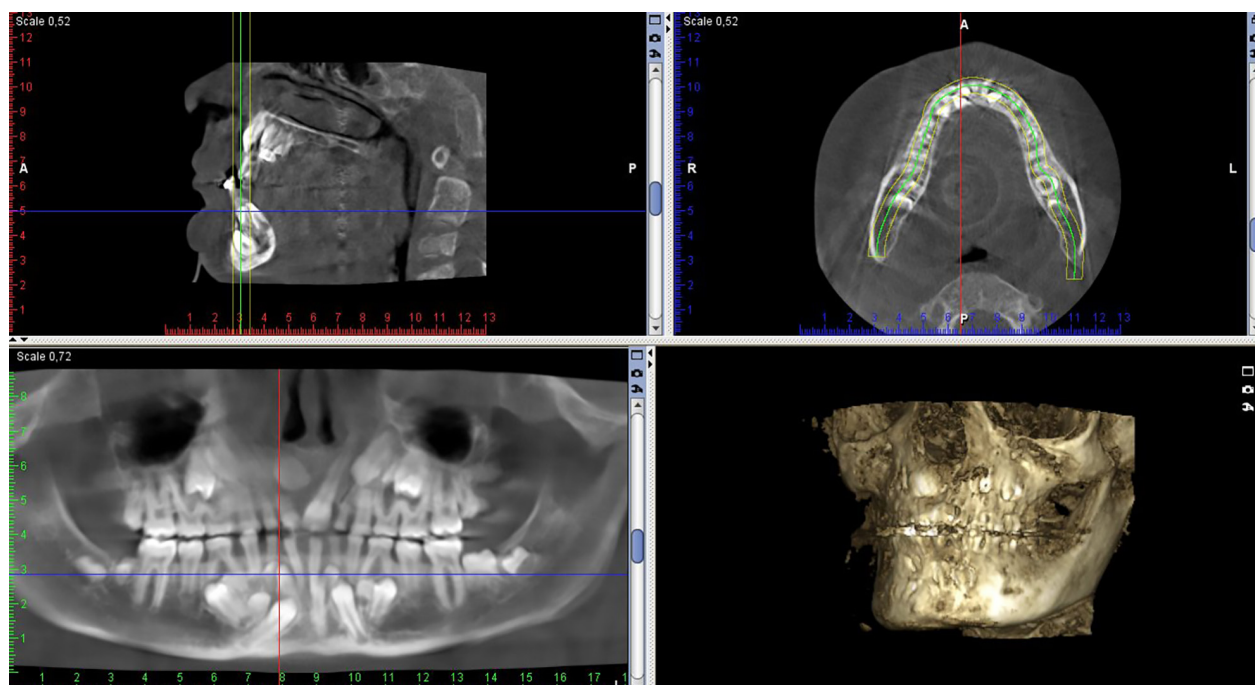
CBCT on patient A.K. in 2017.
